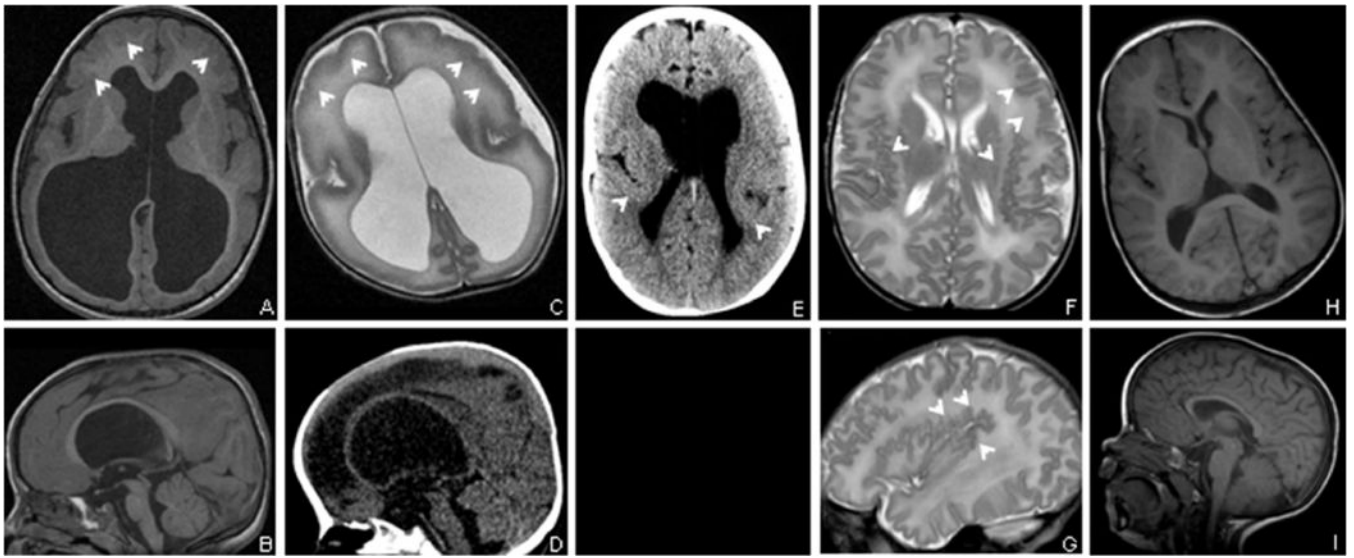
Representative MRI and computed tomography (CT) images from patients with *CULAB* variants. A and B: Family 10—individual II-1 (2.5 years): MRI T1 axial (A) and sagittal (B) sections show severe ventricular enlargement (colpocephaly), arched and thin corpus callosum, and a slightly thick and undersulcated cortex (arrows). C and D: Family 10—individual II-2 (6 months, before placement of VP-shunt): MRI T2 axial (C) and CT scan sagittal (D) sections show severe ventricular enlargement, arched and thin corpus callosum, and a very simplified gyral pattern (arrows). E: Family 1—individual IV-3 (6 weeks): CT scan axial section shows severe ventricular enlargement and bilateral perisylvian PMG (arrows). F and G: Family 11—individual II-2 (Day 13): T2 axial section (F) and parasagittal section through left perisylvian area (G) show bilateral perisylvian PMG (arrows). H and I: Family 2—individual III-1 (2 years): T1 axial (H), and sagittal (I) sections show a mild predominantly posterior ventriculomegaly and a thin corpus callosum.
